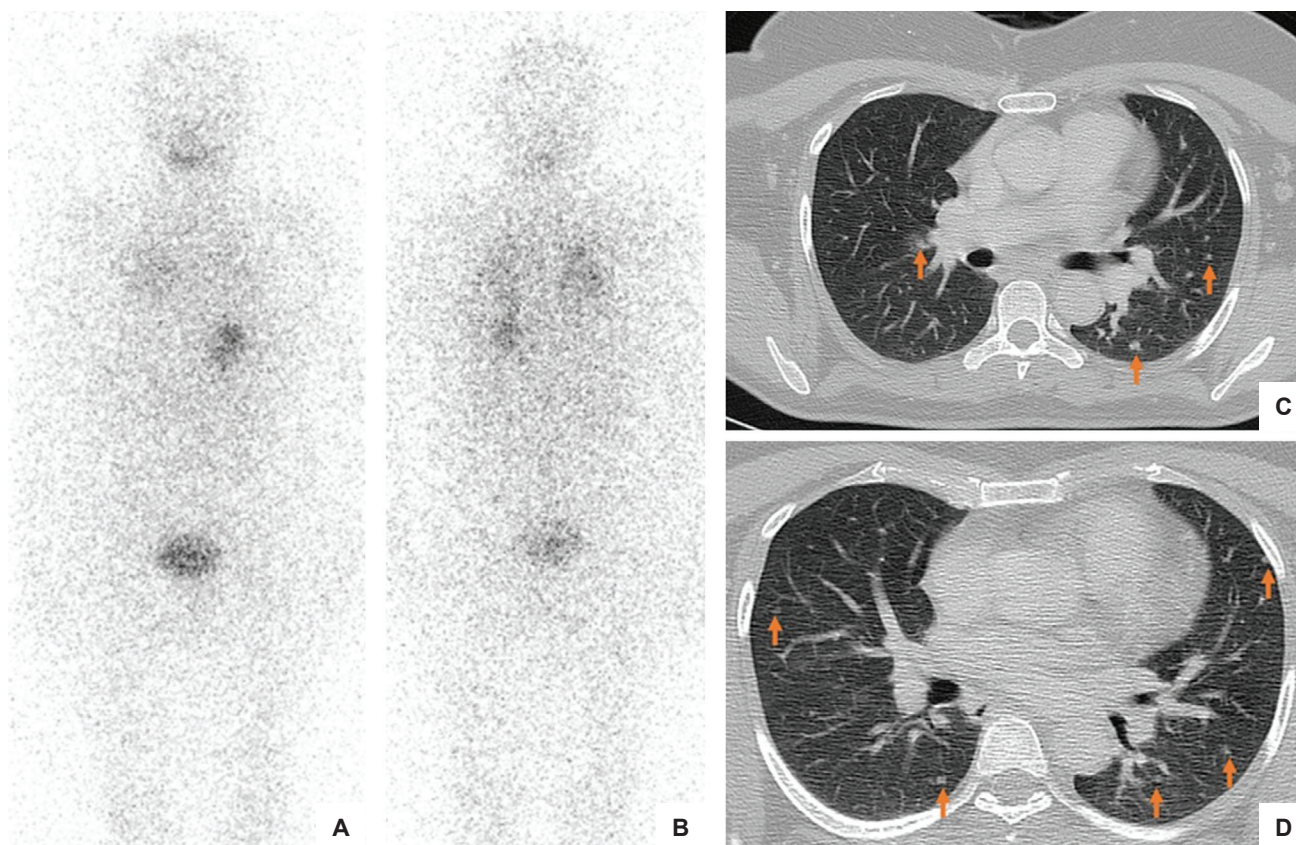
(A,B) Post-operative I-131 scan reveals diffuse radioiodine uptake in the bilateral lungs, corresponding with multiple tiny pulmonary metastases as seen on (C,D) CT images (orange arrows).
